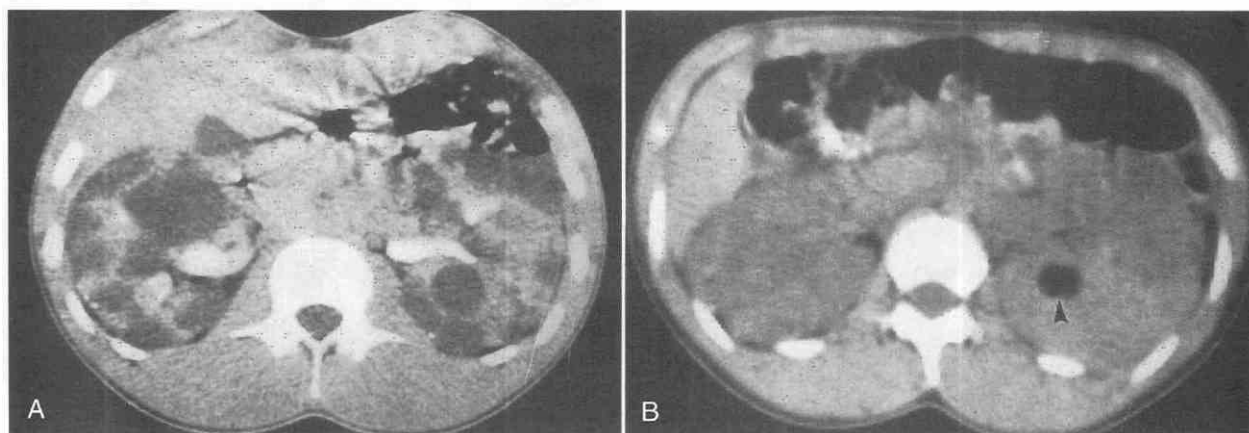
Tuberous sclerosis with renal cystic disease in a 15-year-old female. *A*, Contrast-enhanced CT scan shows enlarged kidneys with multiple fluid-density cysts. The appearances closely resemble that of autosomal dominant polycystic kidney disease. *B*, Unenhanced CT scan shows a 1.9-cm rounded lesion (arrowhead) in the left kidney with a fat attenuation value of 110 HU. The findings indicate an angiomyolipoma and strongly suggest tuberous sclerosis. (From Mitnick JS, Bosniak MA, Hilton S, et al: Cystic renal disease in tuberous sclerosis. *Radiology* 147:85-87, 1983.)
